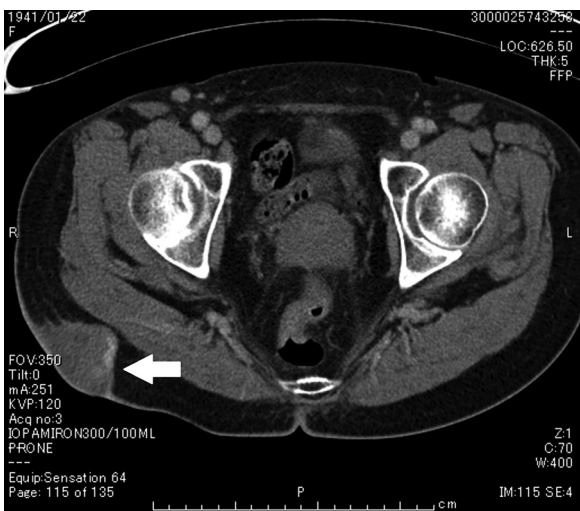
Enhanced computed tomography, showing a homogenous mass with partial ring enhancement (arrow).
